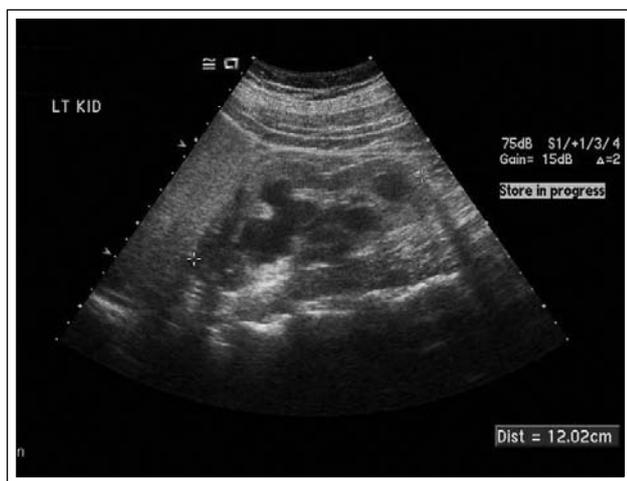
Renal ultrasound revealing grade III hydronephrosis and parenchymal thinning of the left kidney.
